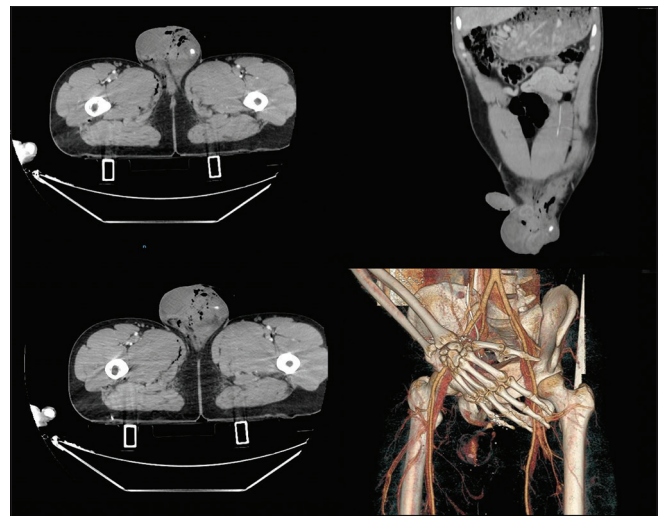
Arterial phase computed tomography abdomen demonstrated an active bleeding from the spermatic cord
